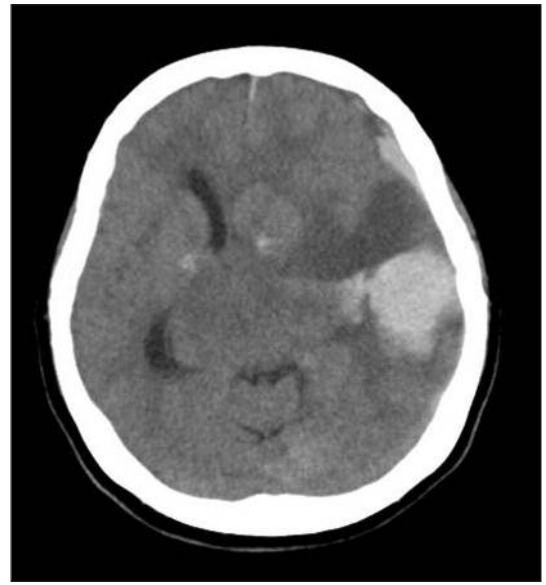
CT scan revealed 6x4,5 cm temporoparietal hematoma with midline shift.
